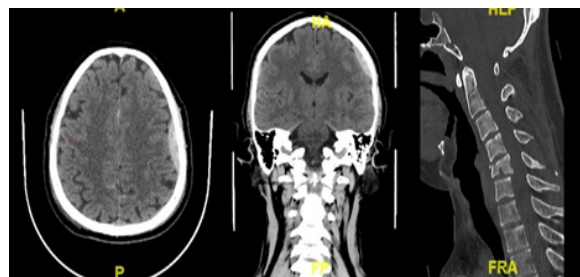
Overview of Head CT scan Examination Results
